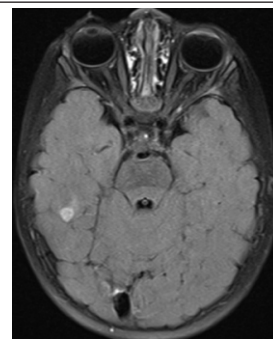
Magnetic resonance imaging brain – tuberculoma.
